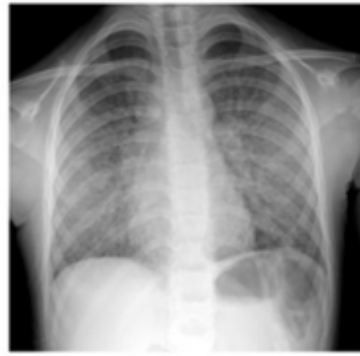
Admission chest-x-ray showing bilateral diffuse micronodules.
